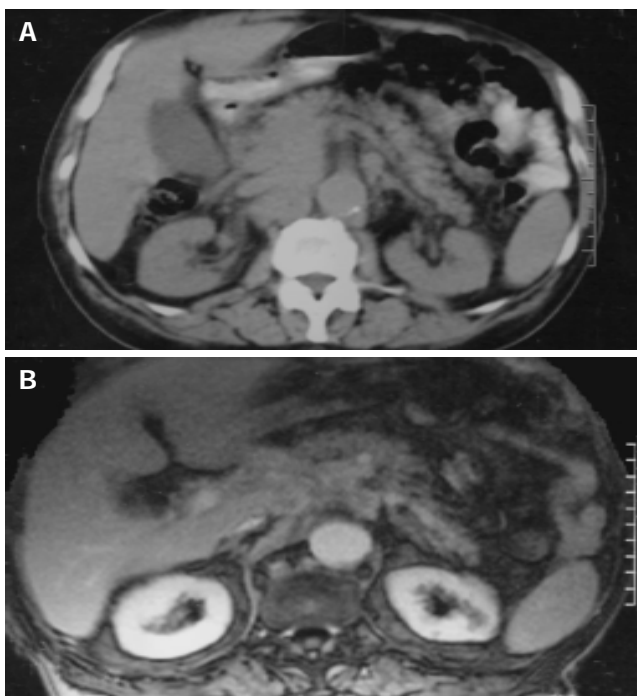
A: Abdominal CT scan showing the head of the pancreas and the uncinate process blurred. B: The mass in the pancreatic head and especially the uncinate process in MRI scan.
